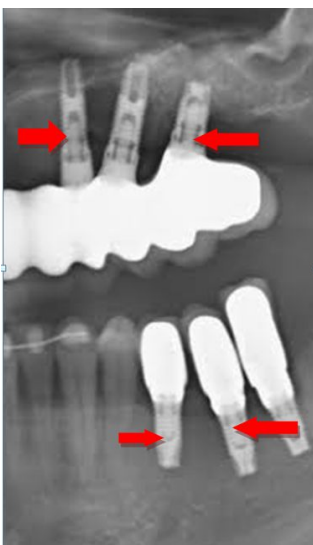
Radiographic aspect of endoimplantiasis (spaces "empty"). HE 3,75 mm 10 mm (Exopro S/A, P-I Bra°nemark Philosophy, Bauru, Brazil)
